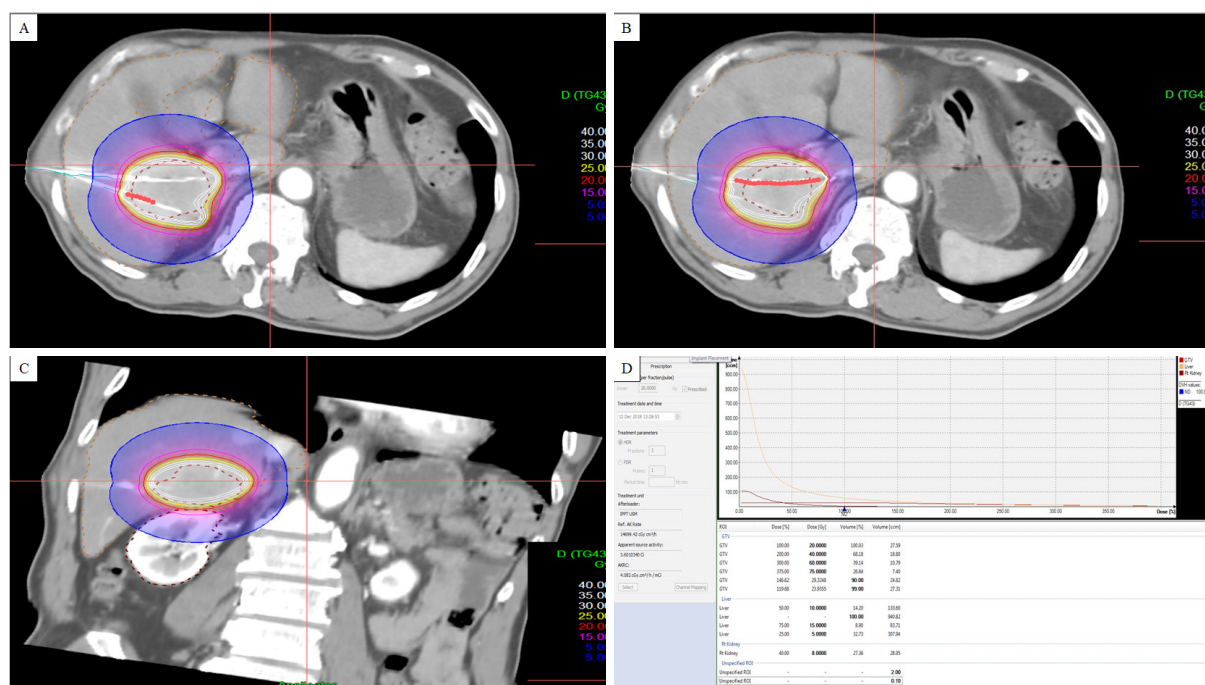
Example of a CT HDRBT plan for a single hepatic metastasis. axial images; the patient has 2 after-loading catheters advanced into the lesion. Dose distribution is adjusted by 3D treatment planning. The planned minimal enclosing dose was 20 Gy (red line) (A, B), coronal image (C), dose-volume histogram (D). HDRBT: high dose-rate brachytherapy
